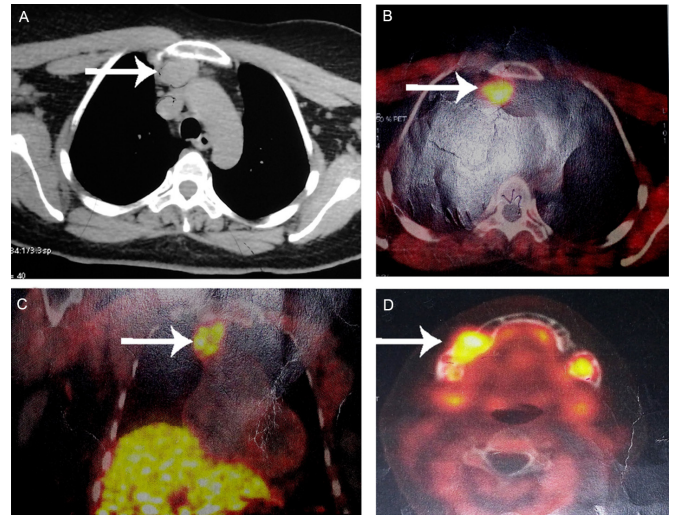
(A) Axial CT image showing superior mediastinal lesion abutting manubrium sterni (white arrow). (B) Axial view and (C) coronal view of choline positron emission CT (choline PET) (maximum intensity projection) of the same showing intense tracer uptake in the lesion (white arrows). (D) Increased tracer uptake is noted in both half of the body of mandible (white arrow).
